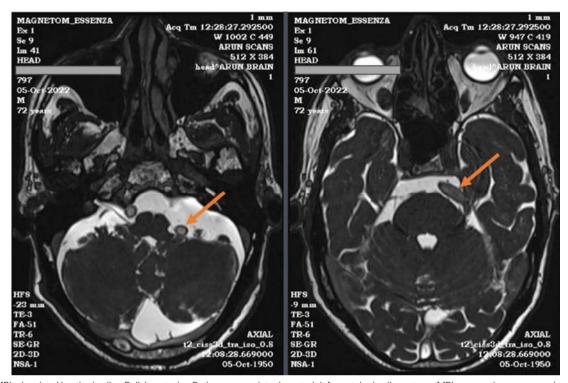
MRI showing Vertebrobasilar Dolichoectasia. Red arrows point elongated left vertebrobasilar artery. MRI, magnetic resonance imaging.
